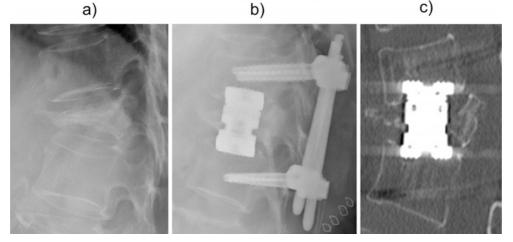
A 62-year-old woman with a fracture of the 12^{th} thoracic vertebral body. Preoperative lateral radiograph: Kyphotic angle was 34° in the intermediate position, and intervertebral height at the center of the vertebral bodies was 24 mm (a), postoperative lateral radiograph: kyphotic angle of 17° (b), postoperative sagittal computed tomography scan (c); the end plate was damaged during insertion of the cage because of the narrow space between Th11 and L1.
